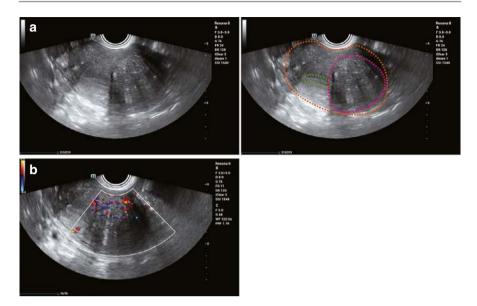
(a) Focal adenomyosis located in the left wall of the uterus, with poorly defined borders between the adenomyosis, the myometrium, and the endometrium. The uterus is circled in orange; the endometrium is circled in green; the adenomyoma is circled in pink. (b) Color Doppler ultrasound shows increased blood flow in the affected myometrium, without peripheral circumferential blood flow
